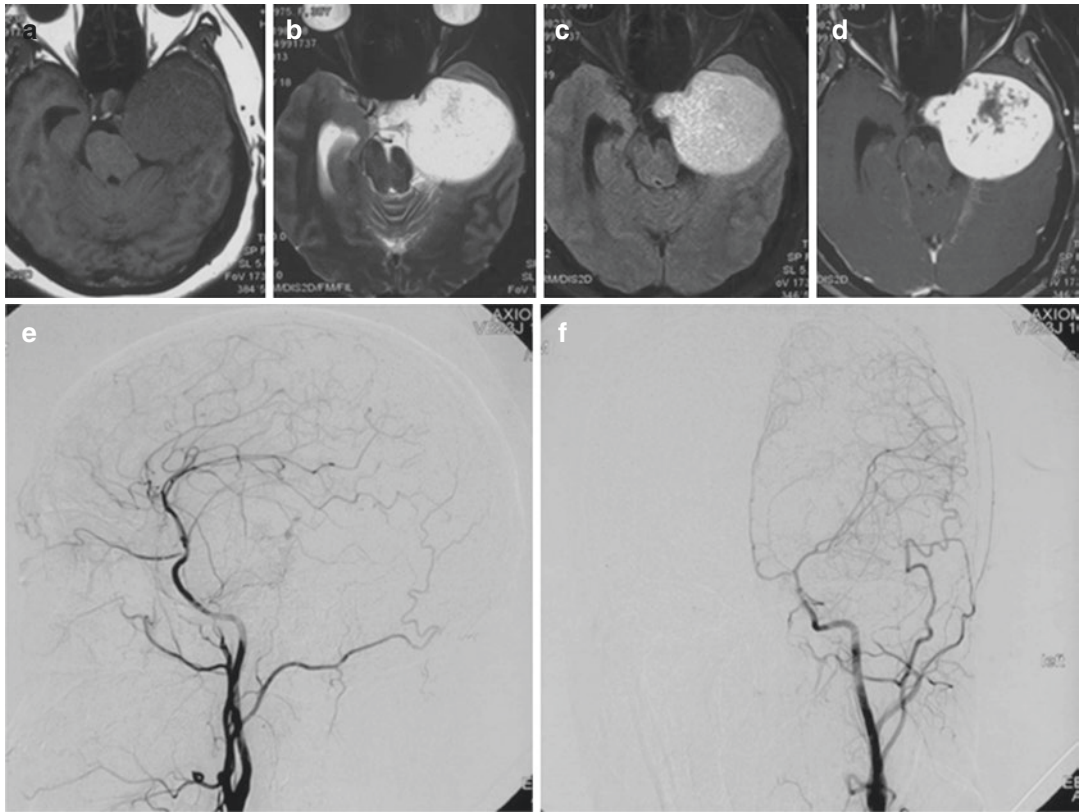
A 32-year-old female had headache and vomiting and MRI examination was performed. The MRI showed low- to iso-signal giant mass on T1-weighted images (a), extremely high signal on T2-weighted images (as bright as cerebrospinal fluid signal) (b), high signal on FLAIR-weighted (fluid attenuated inversion recovery) images (c) and strong homogeneous or heterogeneous
